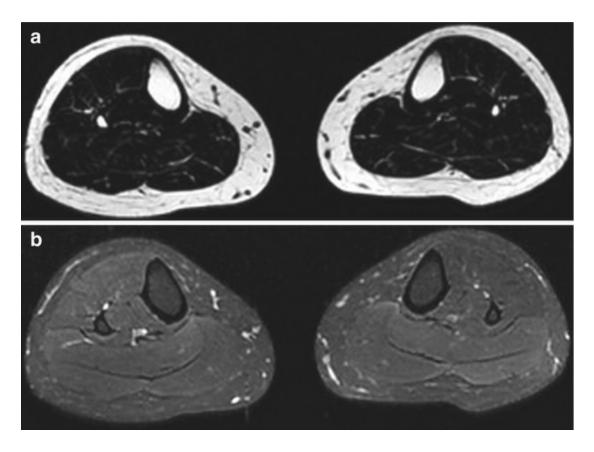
An example of fat-water separation using the IDEAL technique, providing fat (a) and water (b) MRI of the mid legs.
